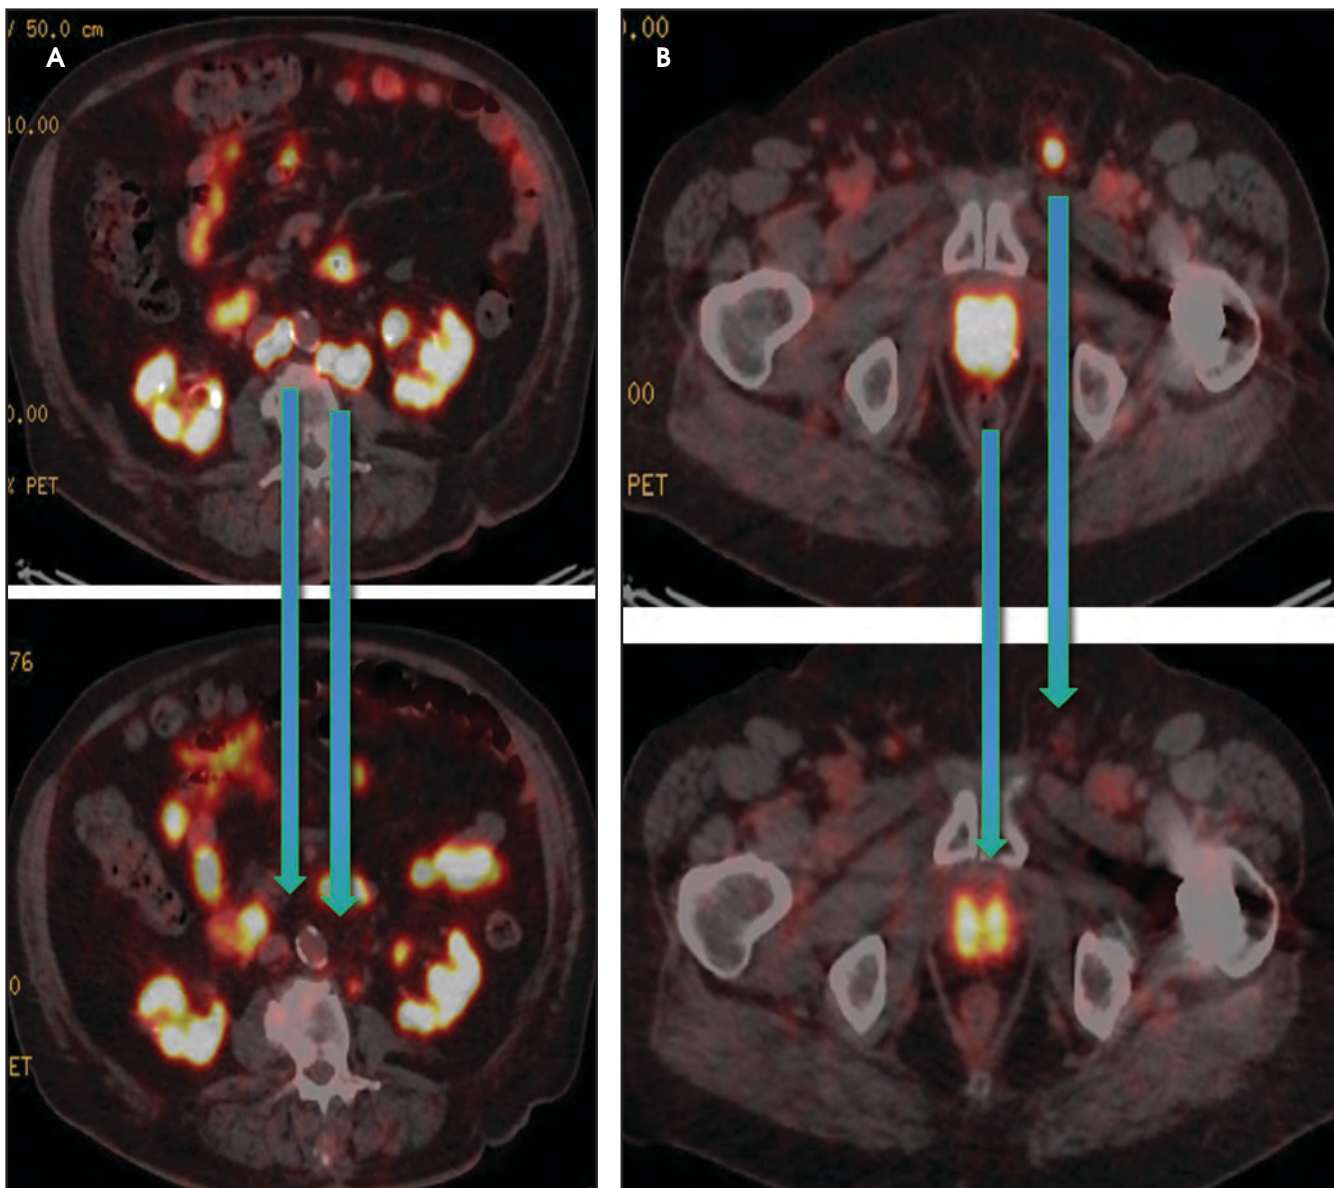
Pretherapy images (upper rows) demonstrate PSMA avid lymph nodes within the aortocaval, left paraaortic and left inguinal regions. Also seen is focal intense uptake localizing to the prostate. Resolution of these lymph nodes is noted on the post therapy images (lower rows). In addition, there is improvement in the level of PSMA uptake localizing to the prostate.
